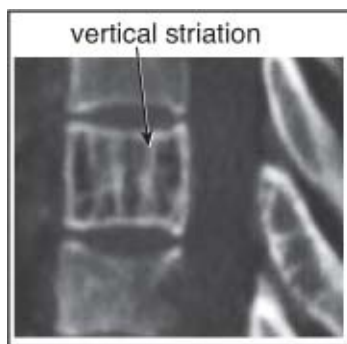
Vertebral hemangioma. Sagittal CT reconstruction
